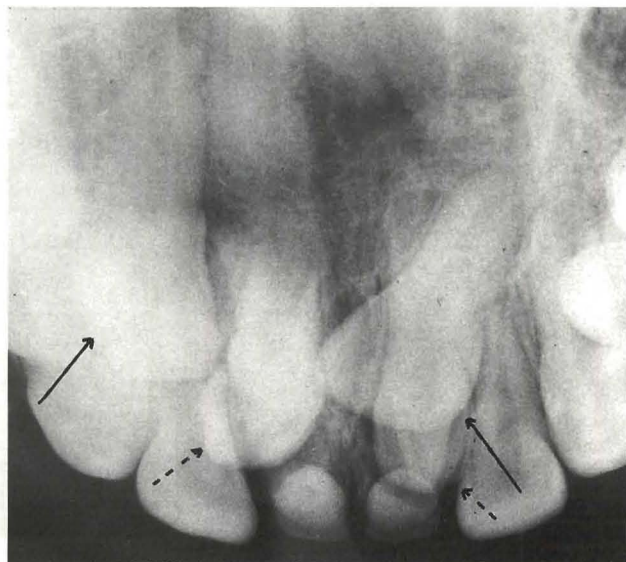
Radiograph showing two tuberculate type supernumerary teeth causing the impaction and displacement of the maxillary permanent central incisors. Dotted lines indicate supernumerary teeth; straight lines indicate impacted permanent teeth.
